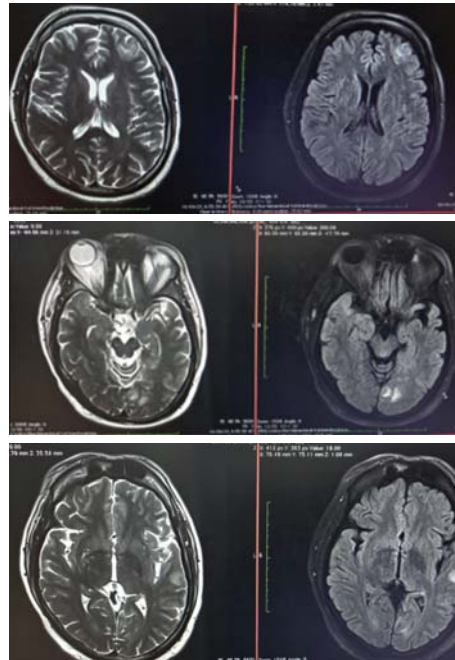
Pre-treatment MRI brain with contrast
